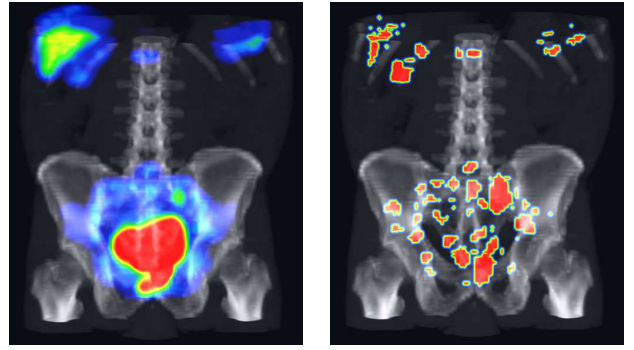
Left: Coronal view of a SPECT-CT lymph node image representing several hot spots over the injection region, in kidneys, bones and liver as well. Right: The result of the SPECT hot spot detection step (I_{sp}^s) fused together with the original CT.
